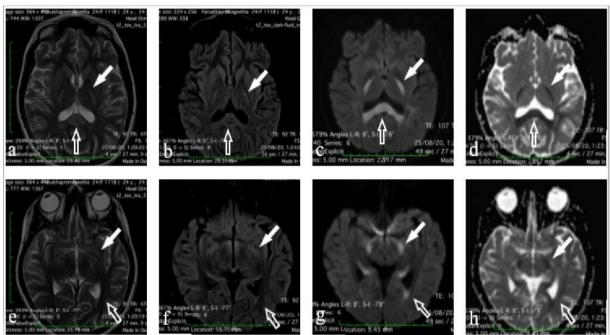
MRI axial sections of the same patient showing T2W image (a, e), FLAIR (b, f), DWI (c, g) and corresponding ADC mapping (d, h) reveals symmetrical T2 /FLAIR hyperintensity in bilateral posterior limb of internal capsule (solid arrows in a-d), hippocampus (solid arrows in e-h), periventricular white matter of occipital horns (open arrows in e-h) and hyperintensity in splenium of corpus callosum (open arrows in a-d) which showed diffusion restriction.
